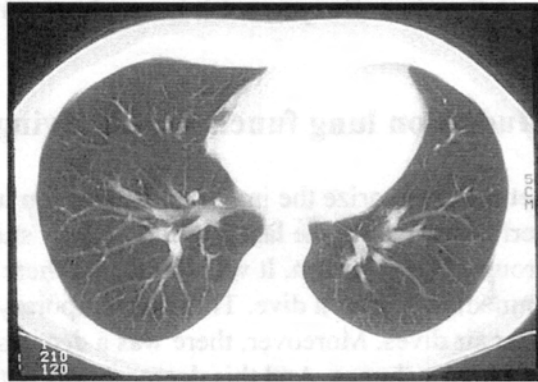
Chest CT of a 29 year old male military diver (Case 6).
